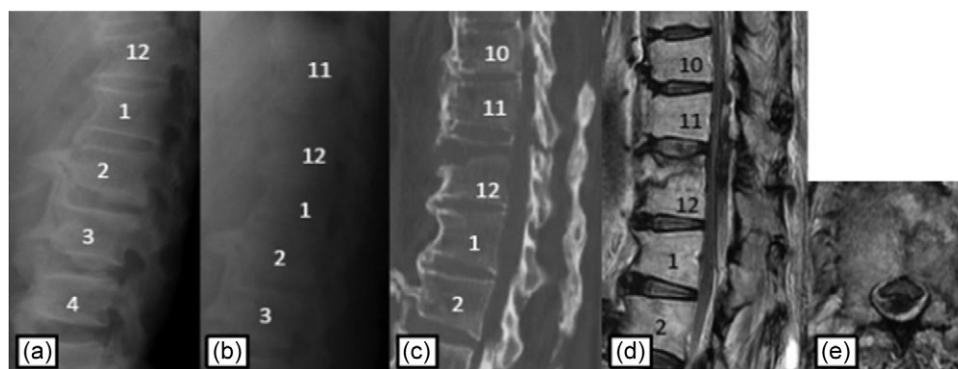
Plain radiographs on initial assessment (a) and on admission (b); Sagittal CT image (c) showing the hyperextension fracture at T12; MRI T2-weighted image (d, e) showing the epidural hematoma compressing the dura matter.
